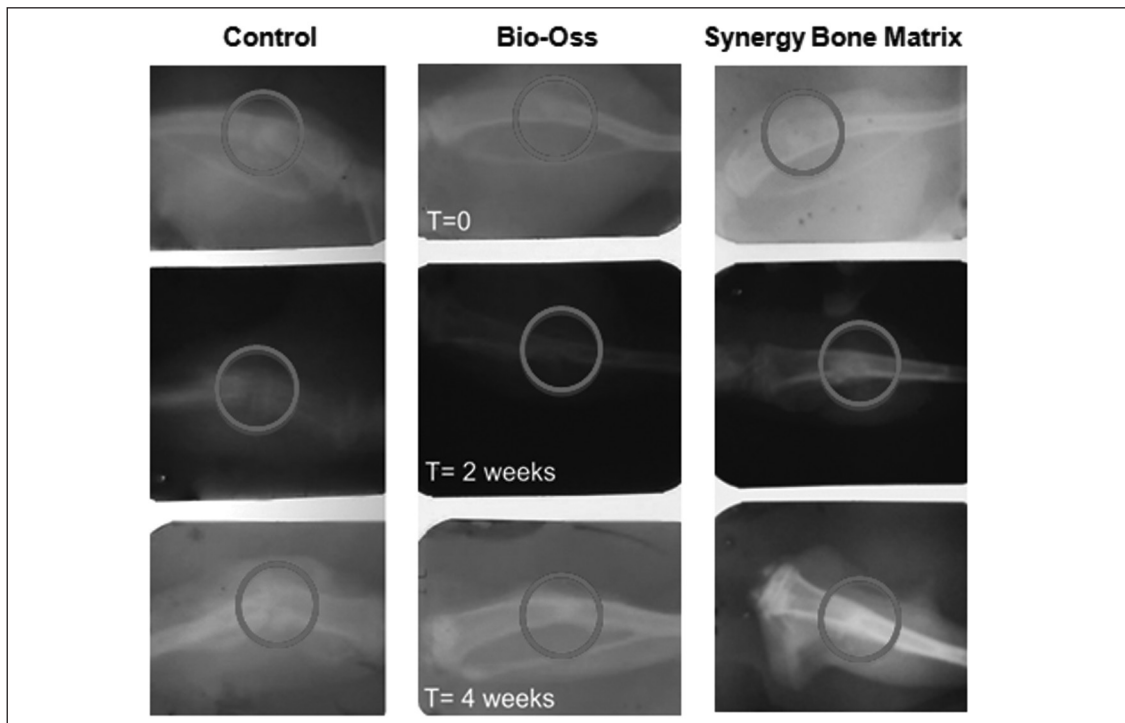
X-Ray images. Control. T= 0: a radiolucent circumscribed homogeneous round area was observed T= 2 weeks: a radiolucent area compatible with a bone defect. T= 4 weeks: Left tibia exhibited a fracture in the area where the bone defect was created. A radiopaque zone surrounding that area, compatible with fibrous tissue was observed. Bio-Oss and Synergy Bone Matrix. T= 0: a radiolucent area surrounded by a minimum thickness radiopaque cortical was observed. T= 2 weeks: a slightly diffuse radiopaque structure found compatible with bone graft structure was observed. T= 4 weeks: a less heterogeneous diffuse zone with osseointegration of bone graft material was observed, giving a radiological image compatible with alleged bone mineralization.
